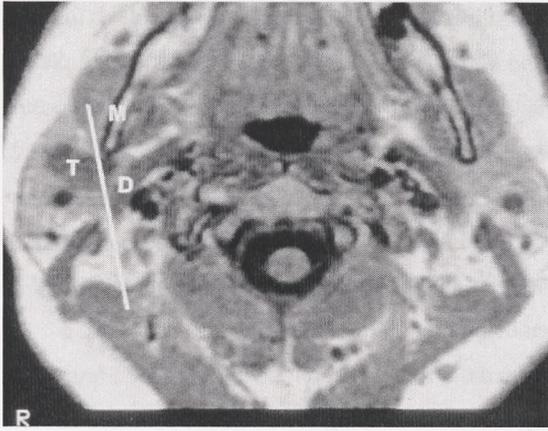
Axial Magnetic Resonance Image of a parotid gland tumour. According to the FN line, this tumour should be superficial. However, at surgery, the tumour was found in the deep lobe. D = digastric muscle, M = mandible, T = tumour.
